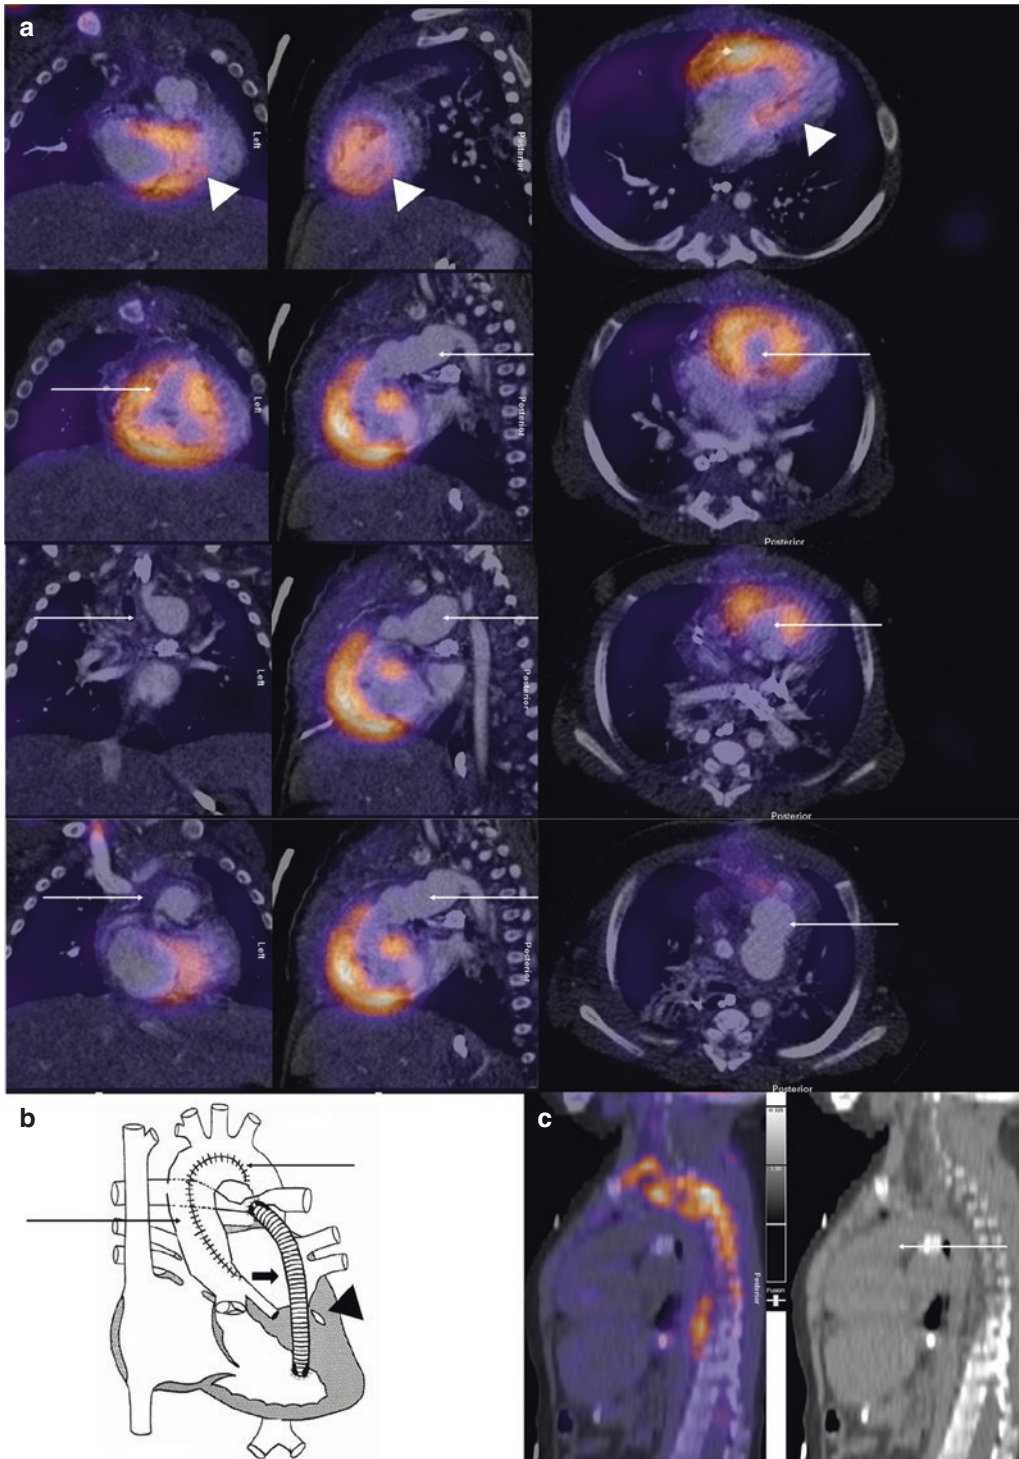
^{18}F -FDG PET/CT performed in a 2-year-old girl with left ventricular and aortic hypoplasia, status post Norwood–Sano procedure. ^{18}F -FDG CT AC images fused with: cardiac CT with contrast (a), cardiac catheterization image (b) and sagittal FDG CTAC PET/CT (c). Visible
